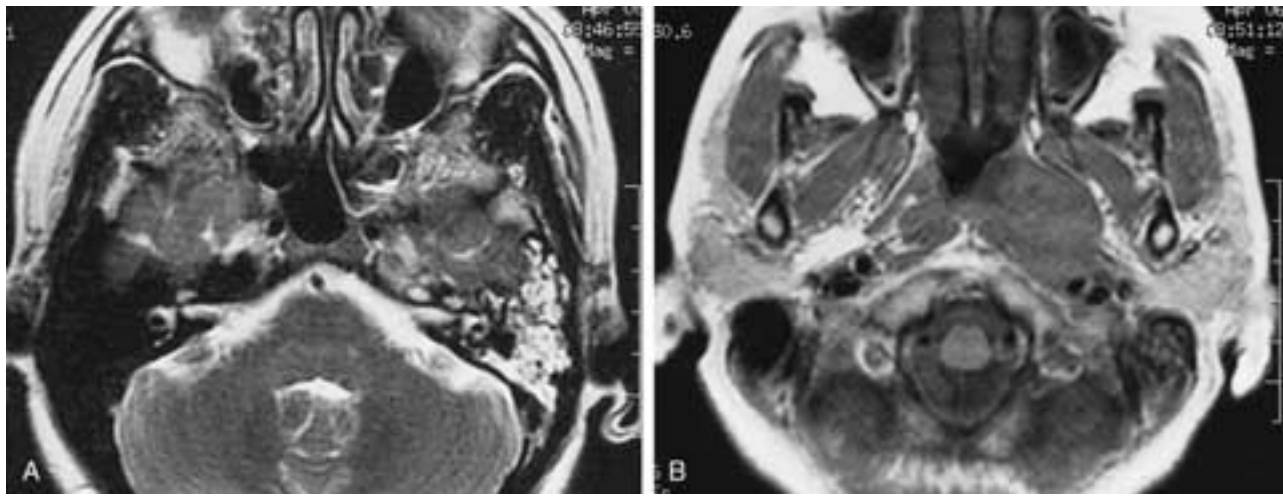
Nasopharyngeal carcinoma, middle ear and mastoid effusion. A, Axial T2-weighted MR image shows fluid in the left mastoid and middle ear. B, Axial T1-weighted image demonstrates a large left nasopharyngeal mass.
